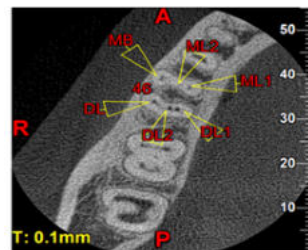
b) CBCT IMAGE WITH NOMENCLATURE
